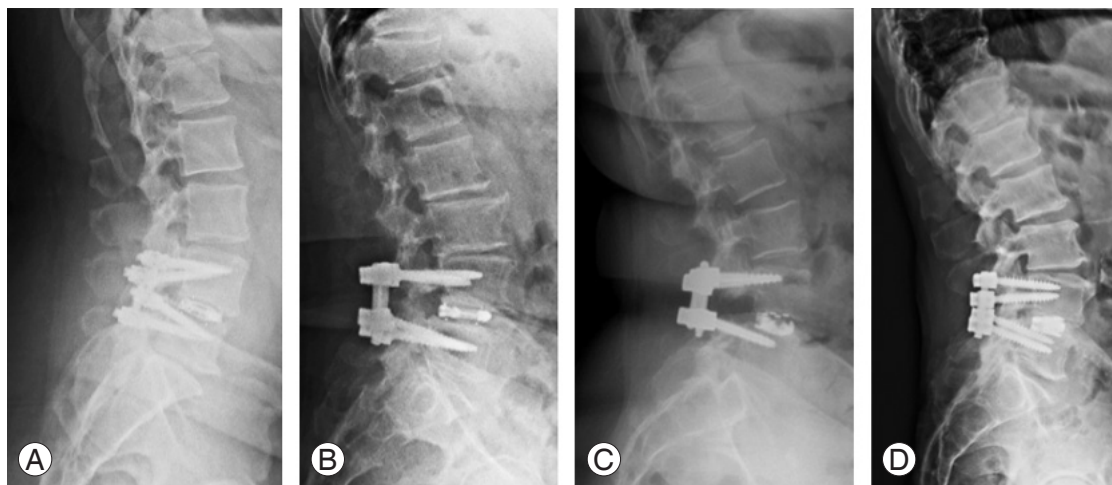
(A-D) Postoperative radiographs demonstrating examples of expandable interbody devices used.
